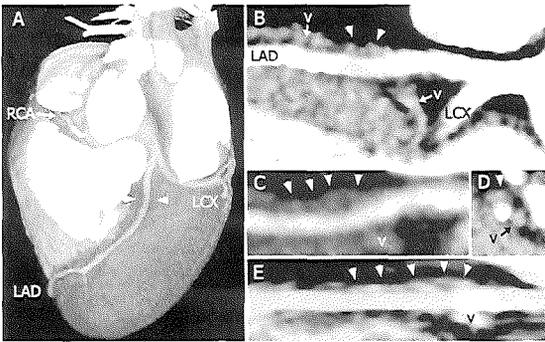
Multislice spiral CT coronary angiogram. A, Volume-rendered reconstruction demonstrates nonsignificant stenosis of the mid-LAD (arrowhead). Maximum plaque diameter was 2.8 mm; minimal lumen area, 5 mm² (2.6×1.8 mm); and reference lumen area, 8 to 9 mm² (3.4×2.7 mm). Longitudinal plaque size is 13 mm. The multiplanar, cross-sectional images show slight narrowing of the LAD (B). The attenuation value of the plaque was measured as 80 Hounsfield units, suggesting a mixed plaque composition without calcification (C and D, arrowheads). The entire segment can be shown in a single plane by means of vessel tracking (E, arrowhead). The great cardiac vein can be differentiated from the plaque by the higher and homogeneous attenuation of the venous lumen (v). RCA indicates right coronary artery; LCX, left circumflex artery.
